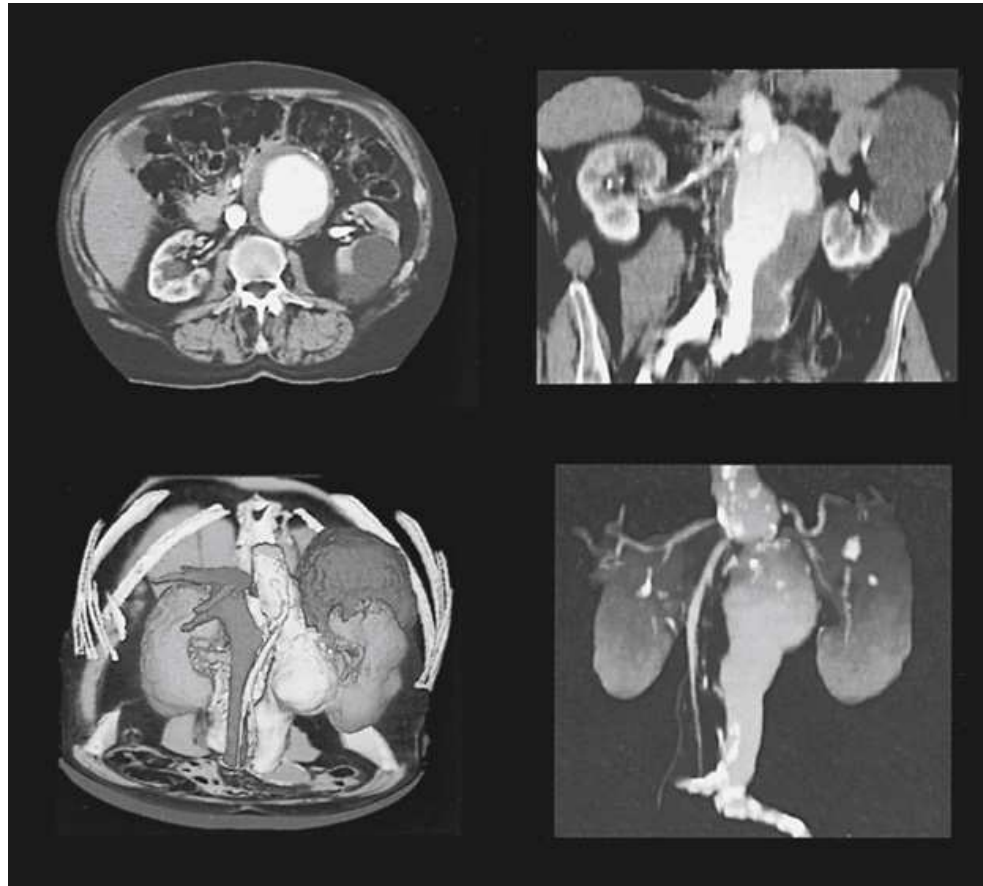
Common three-dimensional rendering techniques used in CT. Courtesy Elicit, Hackensack, NJ.
